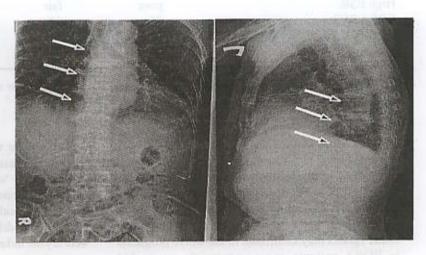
Radiograph of chest on April 30, 2003, there was mild cardiomegaly with generalized interstitial fibrosis.
